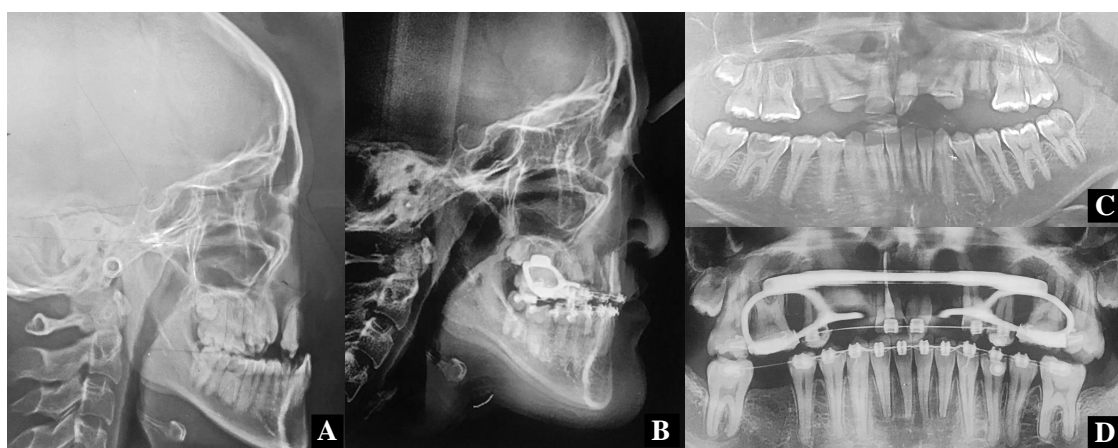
Pre-treatment lateral cephalogram (A), post-treatment lateral cephalogram (B), pre-treatment panoramic radiograph (C), post-treatment panoramic radiograph (D).
